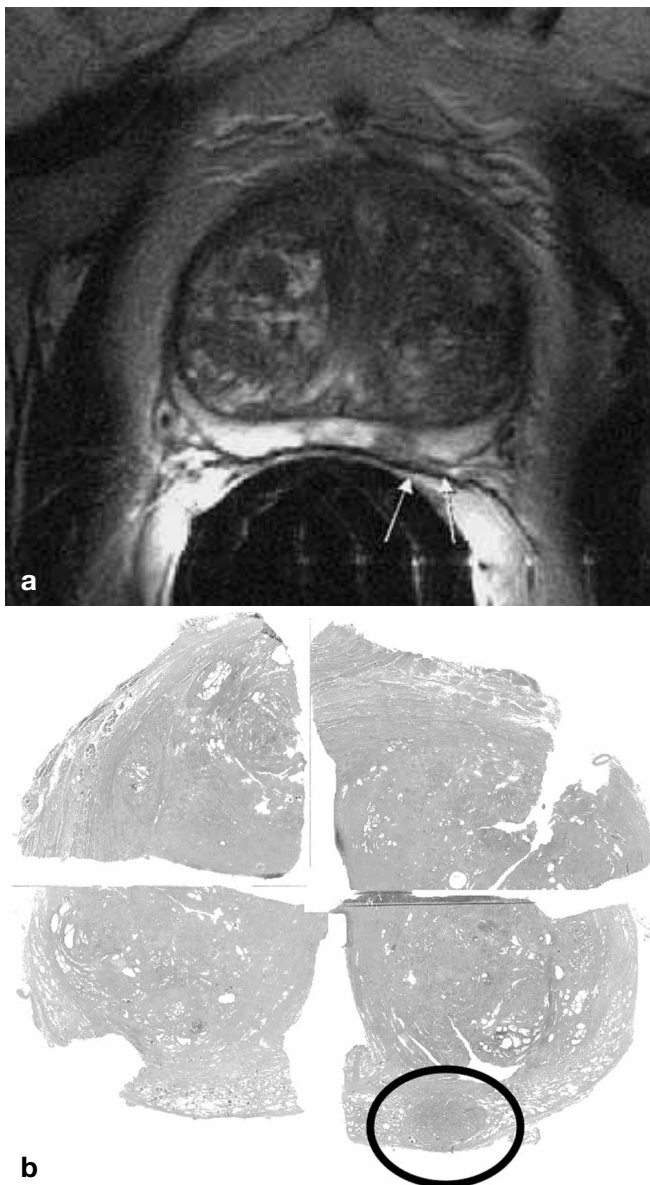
a, b. Patient with prostate cancer with minimal extracapsular invasion. a T2-weighted axial TSE image obtained with endorectal coil (Medrad, Pittsburg, Pa.). Large benign prostatic hyperplasia of central zone shows mixed signal intensity. Tumor (*circle*) is clearly visible as low-signal lesion in high-signal peripheral zone. There is minimal bulging of capsule (*arrows*). b Whole mount section revealed minimal capsular invasion at this site
